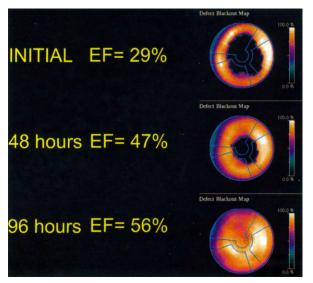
Serial single-photon emission computed tomographic left ventricular polar maps with corresponding left ventricular ejection fractions (EF) at 0, 48, and 96 hours.²⁴ Reprinted from Heart Fail Clin 2013;9(2):123-36, vii. Sharkey, SW. Takotsubo cardiomyopathy: natural history. Copyright (2013), with permission from Elsevier and SW Sharkey.
